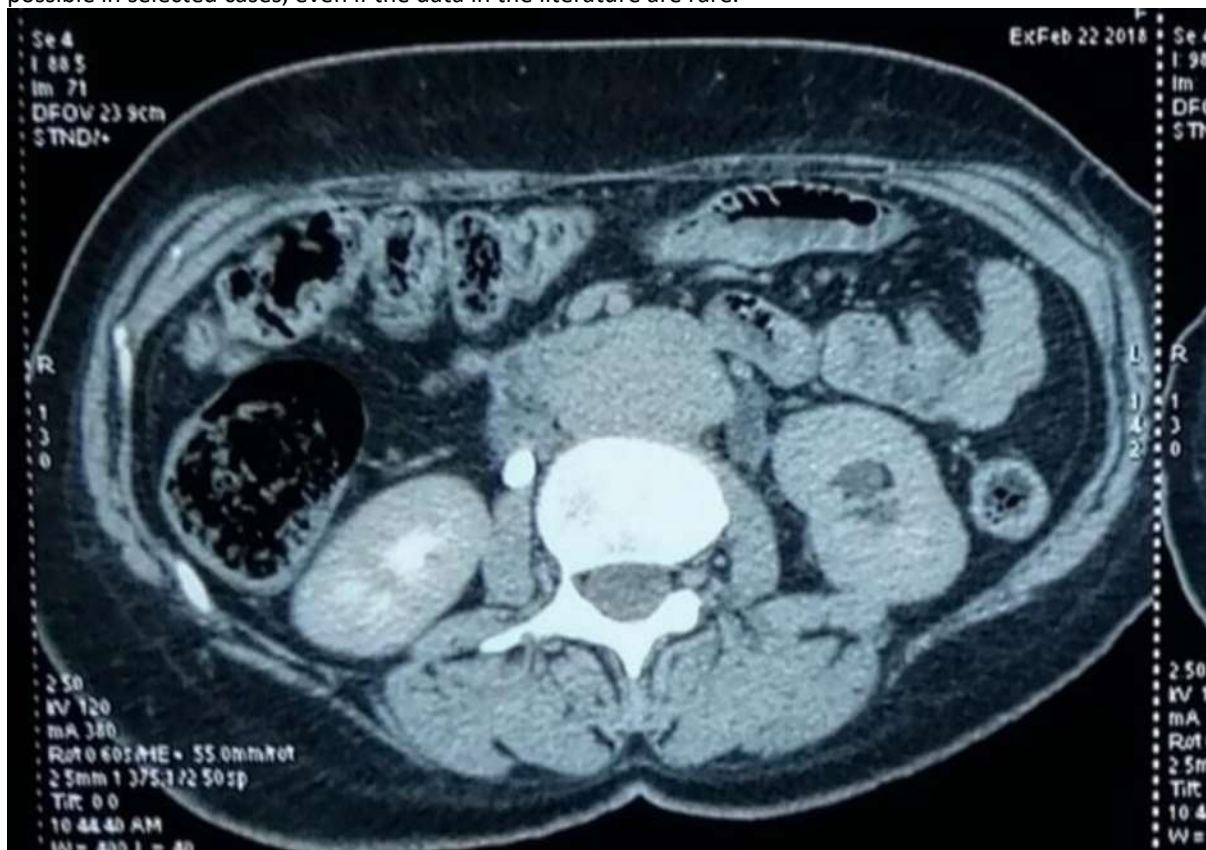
CT shows a retroperitoneal tissue processus incasing the aorta, the vena cava and the left ureter with a ureterohydronephrosis.
